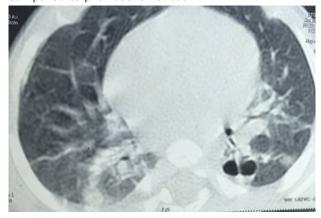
CT chest showing decrease in the lesions as compared to previous CT chest.
